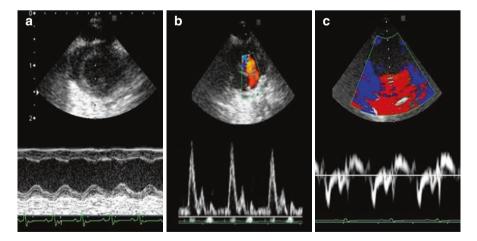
Echocardiography (a) 2D & M-mode. Color Doppler. (b) Spectral Doppler. Mitral inflow. (c) Tissue Doppler. Mitral annulus
